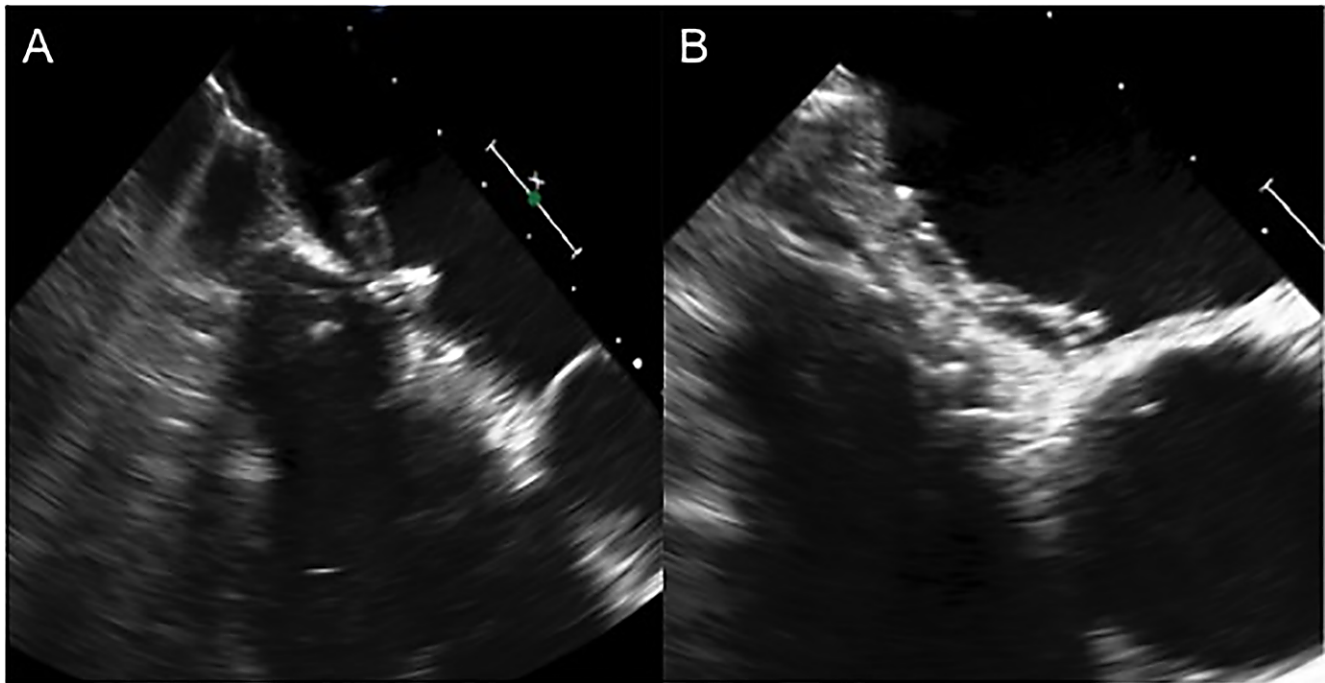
Transesophageal echocardiogram of Cardioform Deployment via right internal jugular vein (*Panel A*). Transesophageal echocardiogram of full Cardioform Deployment (*Panel B*).
